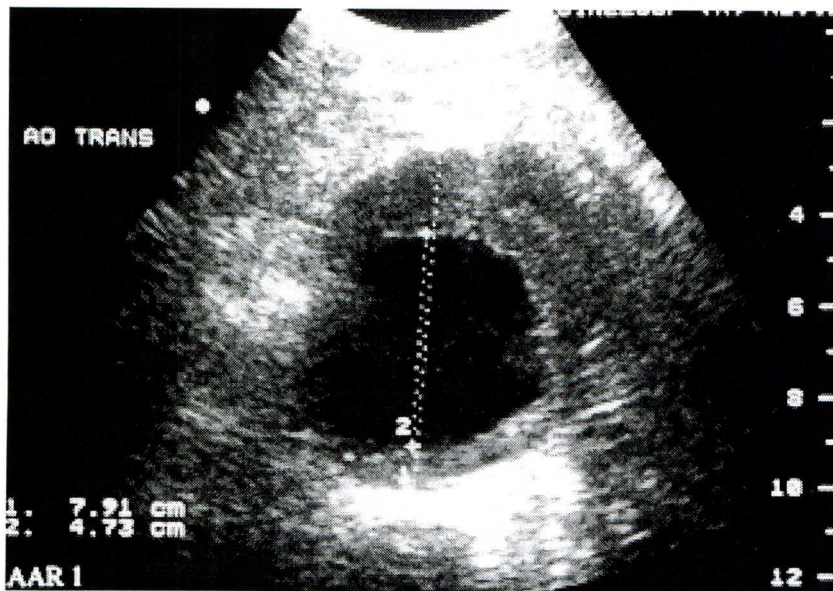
Ultrasound of a large AAA. The Anteroposterior diameter of this AAA measures 7.91 cm; intraluminal diameter is 4.73 cm. Intraluminal thrombus is clearly visible.
